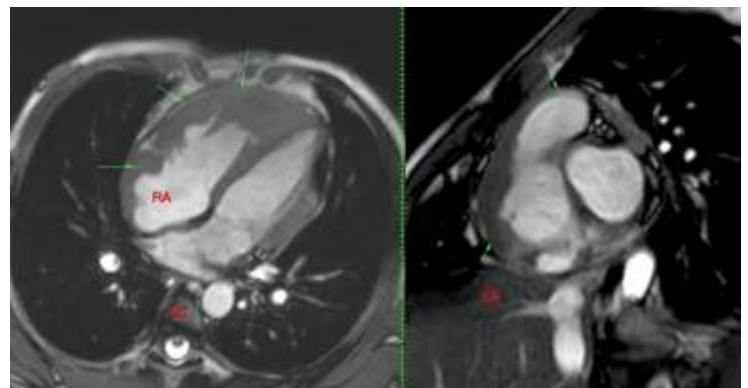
Case 2: 23-years old man with tumefactive TB. Four chamber (4C) and short axis (SA) images show masses involving the RV and RA. An internal epigastric nodal biopsy following a PET/CT confirmed the diagnosis of tuberculosis with follow-up scanning showing significant regression.
